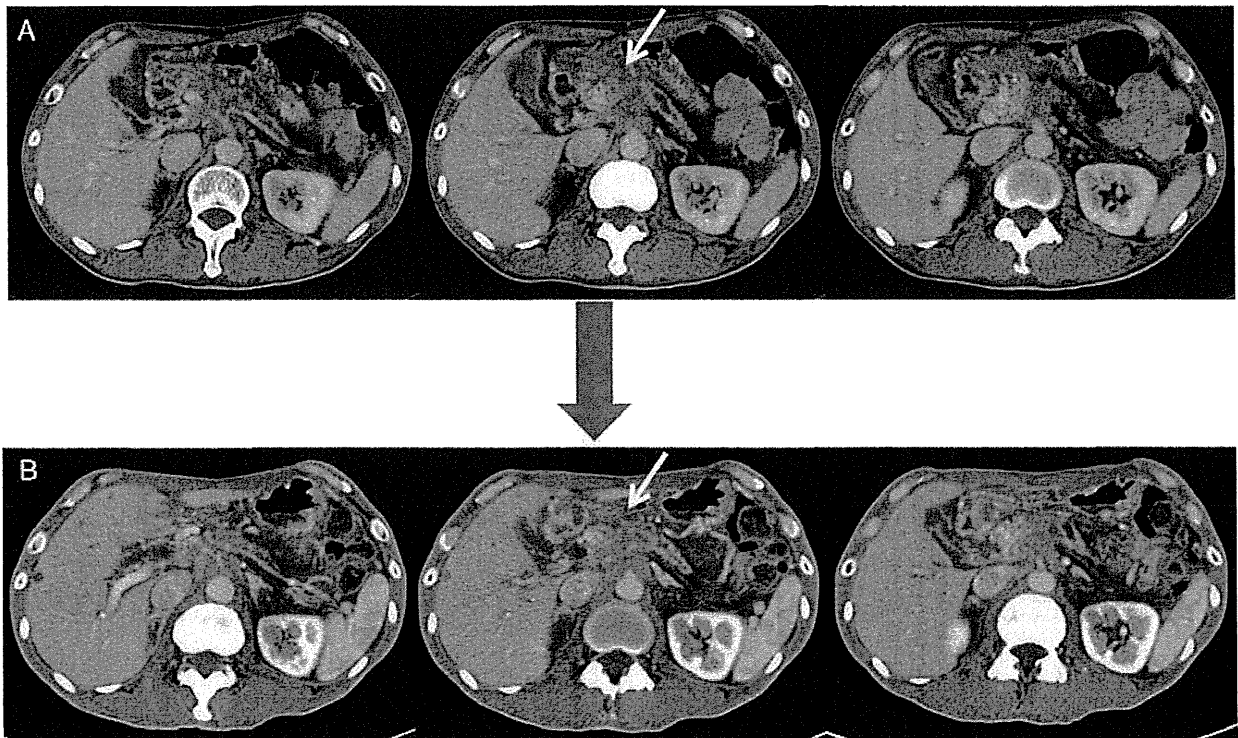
Axial contrast-enhanced computed tomography (CT) scans of patient 3 who showed SD. A, Axial contrast-enhanced CT showing locally advanced tumor of the pancreatic body before vaccination (arrow). B, Axial contrast-enhanced CT after 4 months shows SD of the pancreatic body mass (arrow). SD indicates stable disease.
